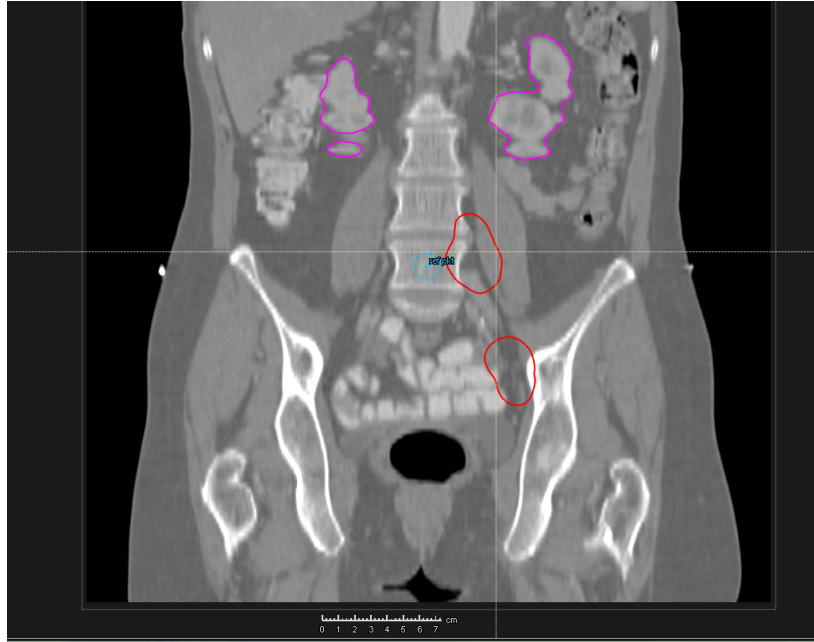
Coronal plane CT view of a patient included in this study, along with delineated clinical structures. The red structures are positive lymph node planning target volumes (PTVs). The pink structures are the kidneys. The image is taken from the RayStation treatment planning system.
